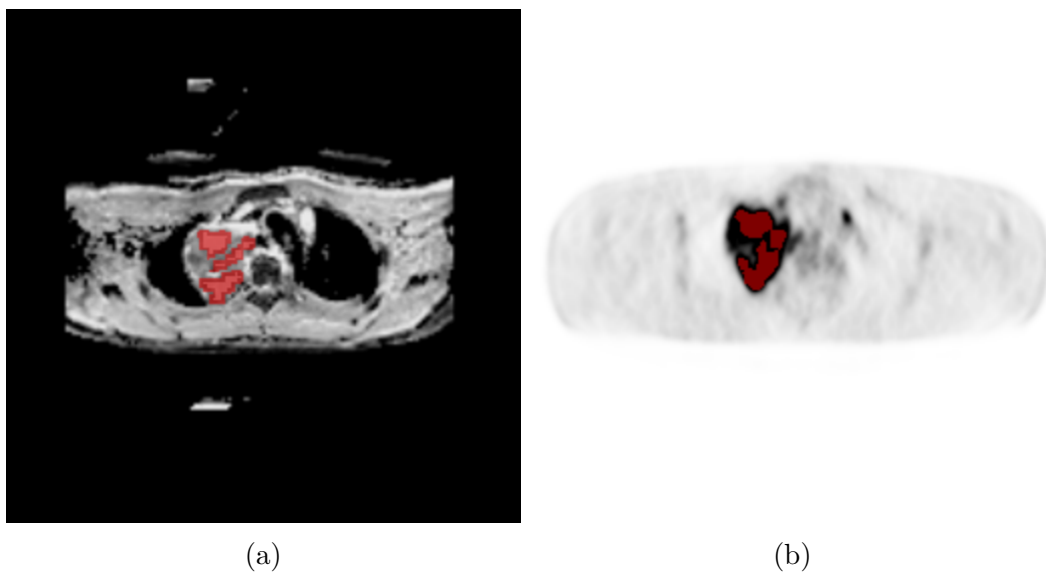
Patient 75, (a) ADC map with manually drawn ROI for ADC analysis, with the whole area of the lesion in red and the inner area of the lesion in light red, (b) PET image from PET/MR with ROI (red), for SUV analysis.
